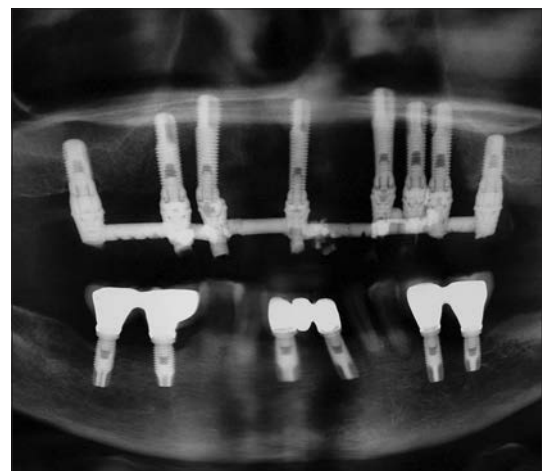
Panoramic radiograph, 2-year follow-up
